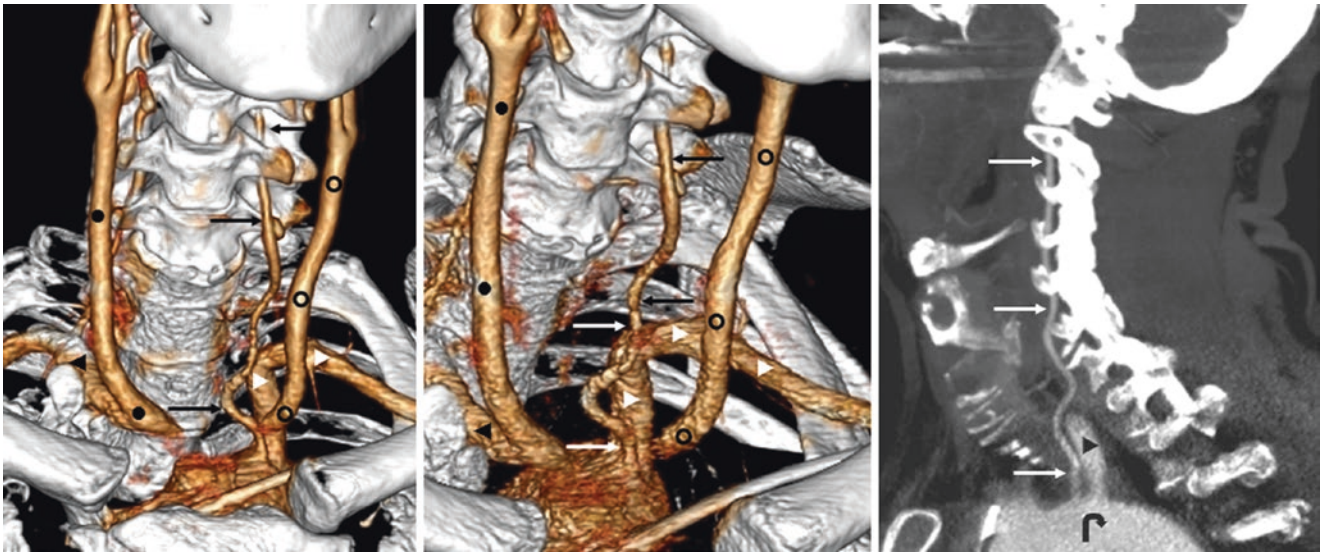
50-year-old with an “arch origin” of the LVA (arrows) on a CTA with 3D VR AP (left) and RAO (middle) views, as well as on a 15-mm sagittal MPR (right). The MPR confirms that the LVA arises just proximal to the LSCLA. Aortic Arch (curved arrows); IA Innominate
